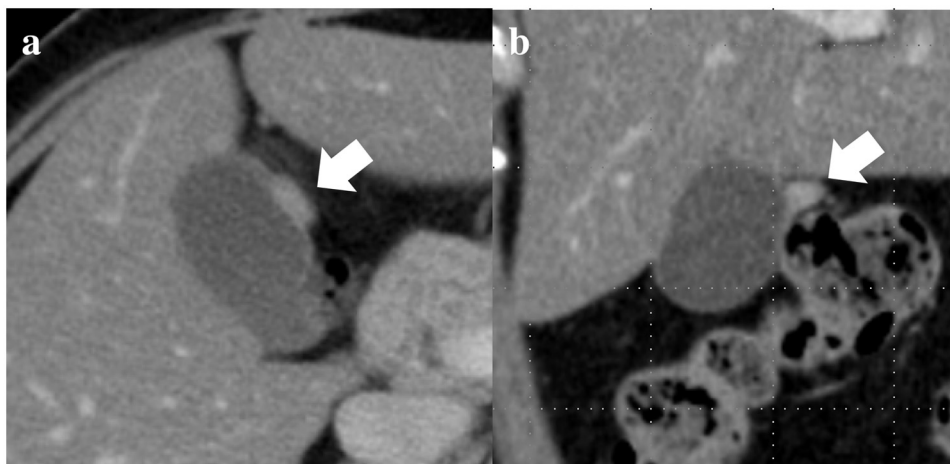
Computed tomography shows the accessory lobe at the surface of gallbladder (arrows) in the (a) transverse plane and (b) the coronal plane.
